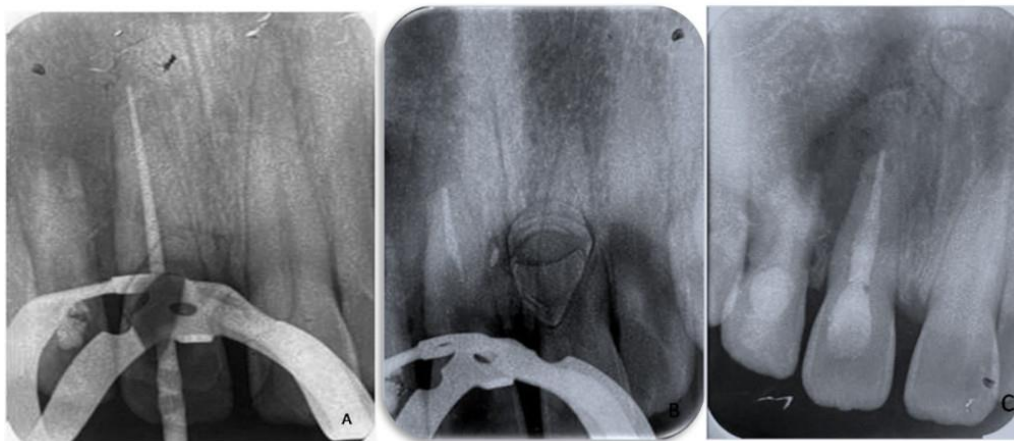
A: Master cone radiograph; B: Gutta-percha cone used to fill the apical root canal; C: Post operative radiograph: Obturation with thermoplasticized Gutta-percha
